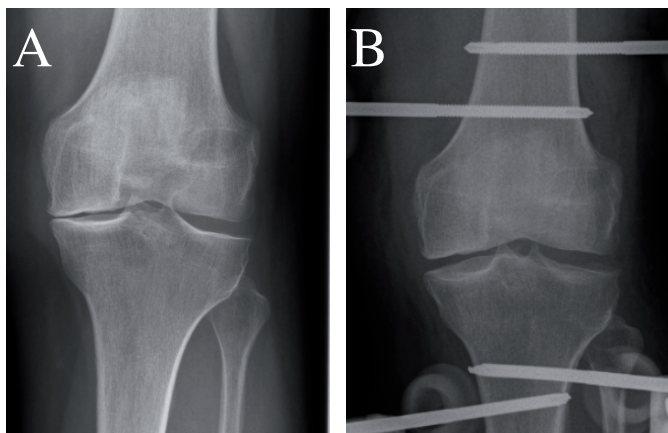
Example of a pre-operative radiograph (a) of a patient treated with knee joint distraction. Radiograph (b) of the same patient during distraction treatment with five millimeters of distraction.
